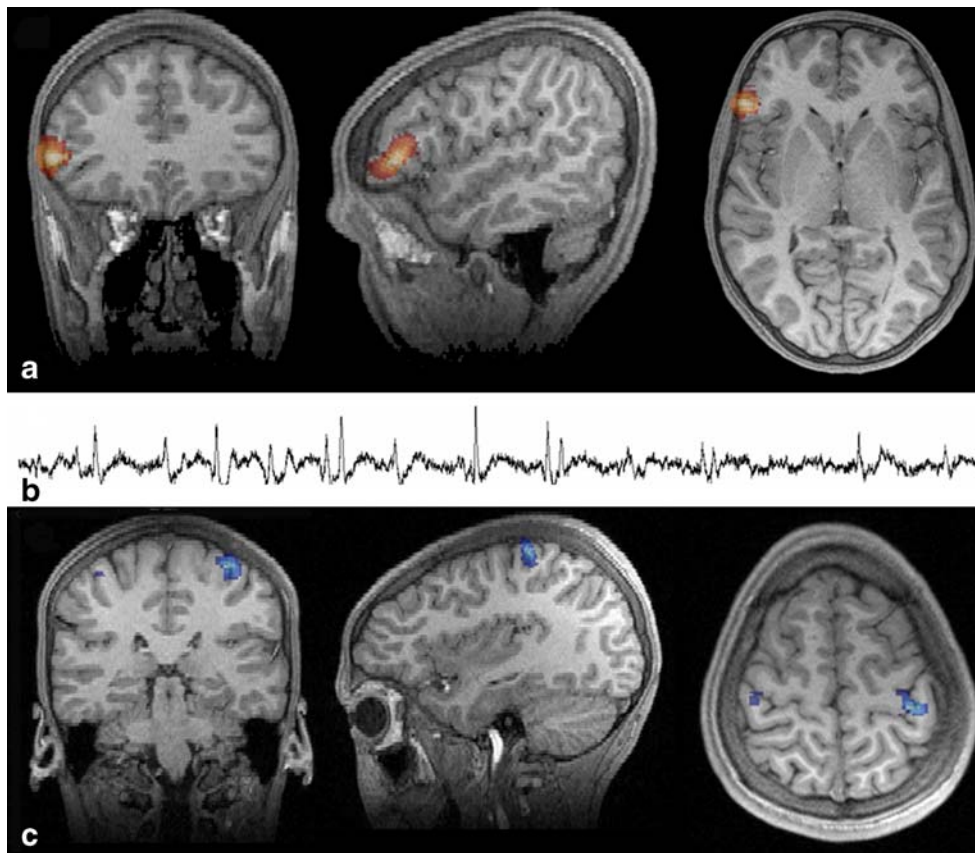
Case 1. a The yellow/red region superimposed on the volumetric T1-W MP-RAGE gradient echo brain MRI indicates the focal epileptogenic zone in the right inferior frontal gyrus. b Approximately 10 s of time activity from a synthetic depth electrode (created at the point of peak activity defined in a) shows very frequent
